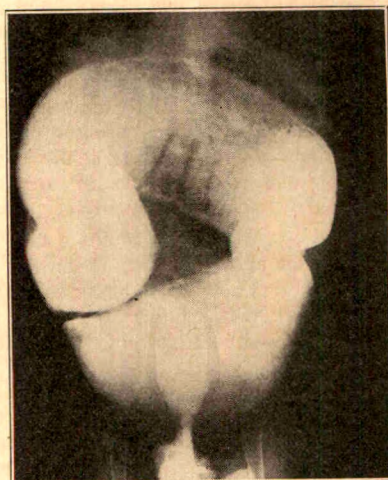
(case 14).—Uniformly enlarged colon terminating in a normal lower segment of sigmoid colon and rectum in a boy 13 months old. A sympathectomy performed thirteen days before the roentgenogram was made did not improve the condition. Death occurred fifty-three days later.
